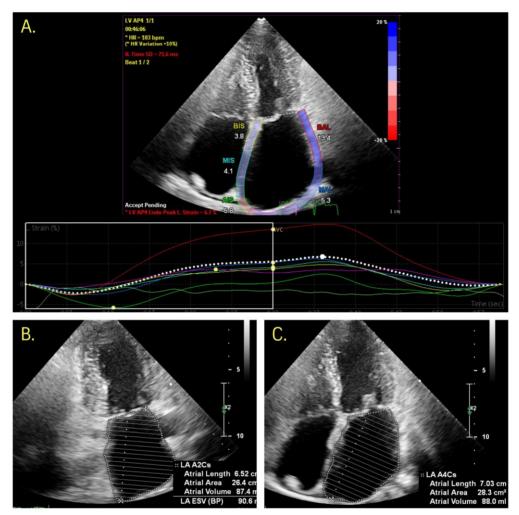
Calculation of peak systolic left atrial longitudinal strain by speckle-tracking B and C. Calculation of left atrial volume via the biplane disc summation technique in the 2- and 4-chamber transthoracic views.
